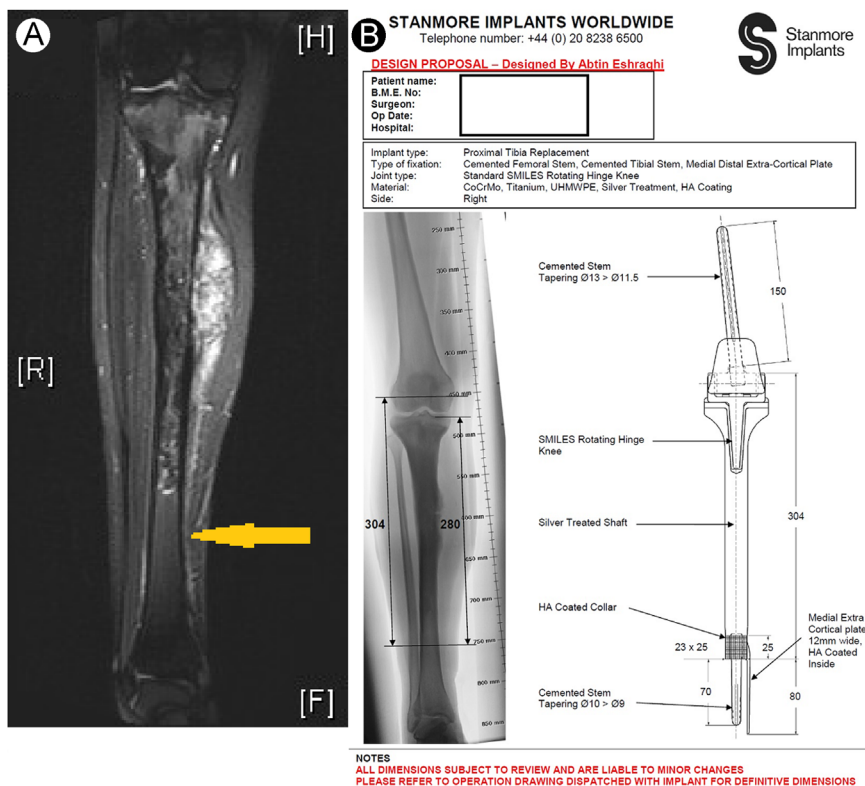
(A) Preoperative T2-weighted MRI scan demonstrating intramedullary extent of tumor and planned resection level (arrow). (B) Design plan of endoprosthesis based on measured radiographs and surgeon’s planned resection level. (Color version of figure is available online.)
